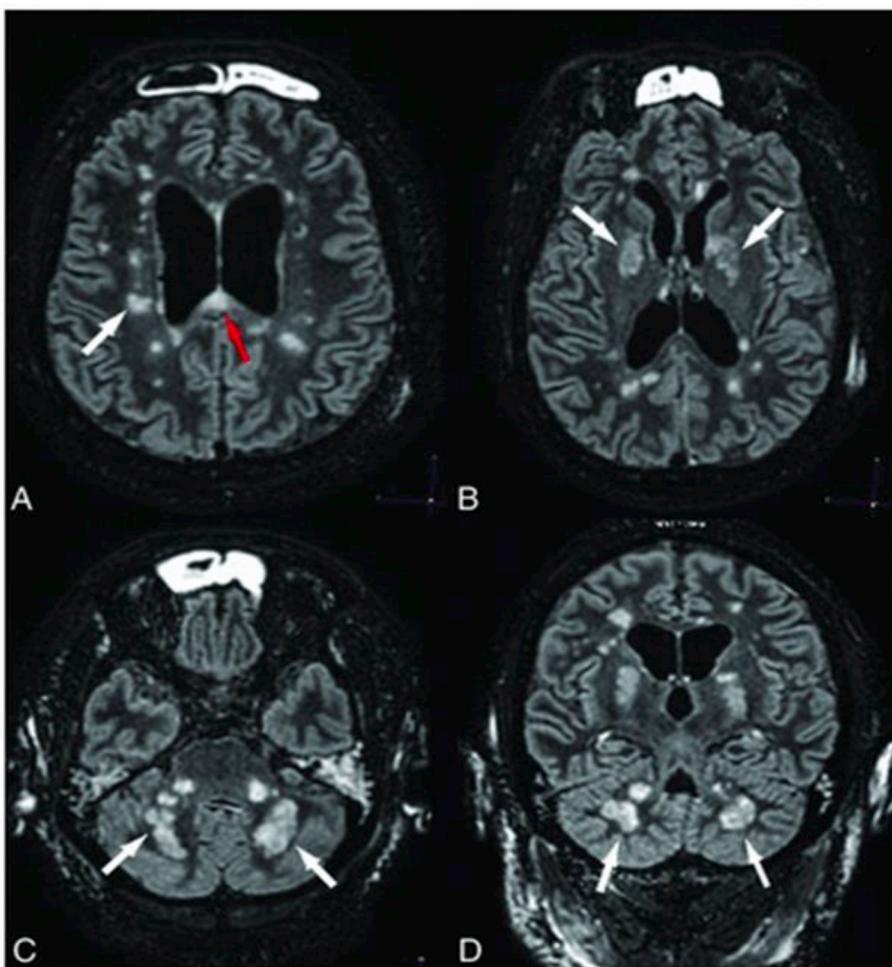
Hyperintense lesions within the periventricular white matter, cerebellar peduncles and basal ganglia (white arrows), and the corpus callosum (red arrow) indicative of diffuse ischemic lesions on the FLAIR image. From Hanafi R, et al. [185]
